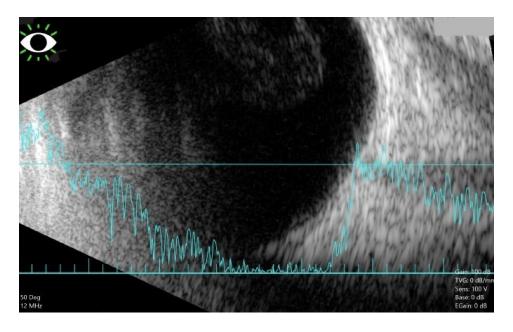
Bscan image OS demonstrating unremarkable ultrasound imaging behind hypermature cataract. No mass or detachment noted giving guarded positive prognosis post-operatively.
